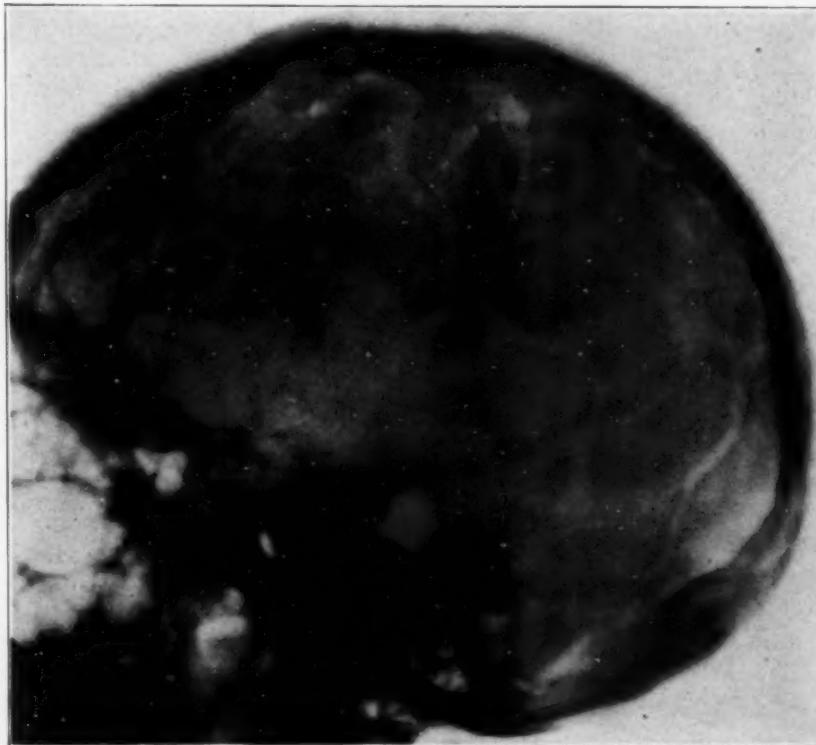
Roentgenogram showing great enlargement of the diploic veins on the right side of the skull. Jacksonian epilepsy affected especially the left arm and hand.
